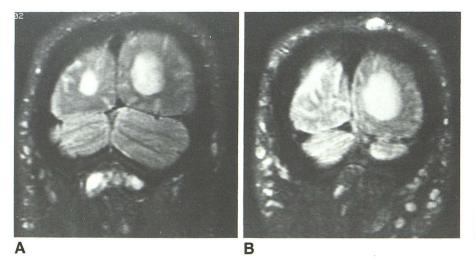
A and B, Coronal T2-weighted MR images of twin 1 (A) and twin 2 (B). Numerous high signal intensity subcutaneous neurofibromas are present in both patients.
